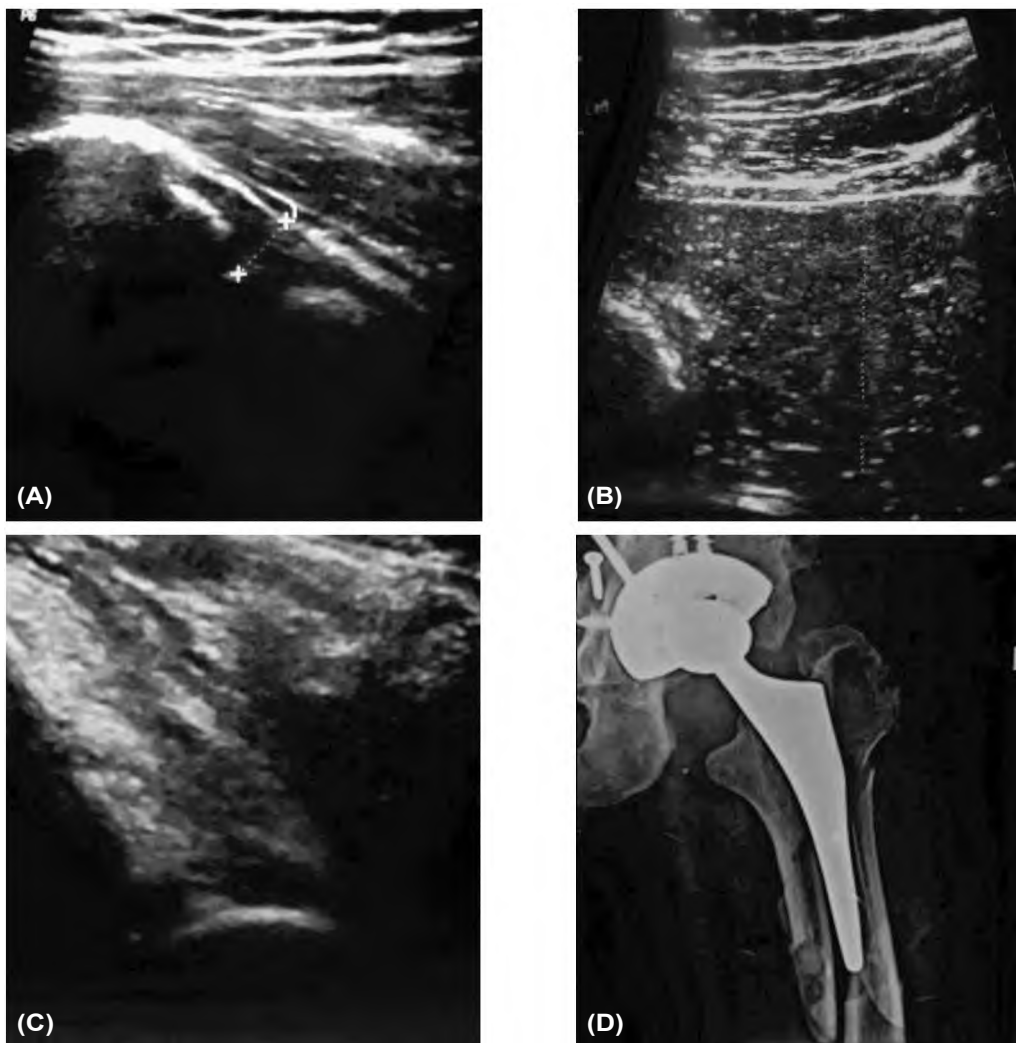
A 28-year-old male patient, known schizophrenic with history of fall from height during suicidal attempt, underwent left THA 5 years ago. (A&B) Joint effusion with bone to capsule distance measuring 7.2mm. Deeply seated well defined lesion of internal echoes and mild vascularity on applying color Doppler (infected hematoma??), not communicating with the joint space. Cortical irregularities with small peri prosthetic calcific foci representing heterotopic calcifications. (C&D) Peri prosthetic femur fracture was diagnosed. Fracture was complicated by infected hematoma causing severe tenderness and high TLC count.
